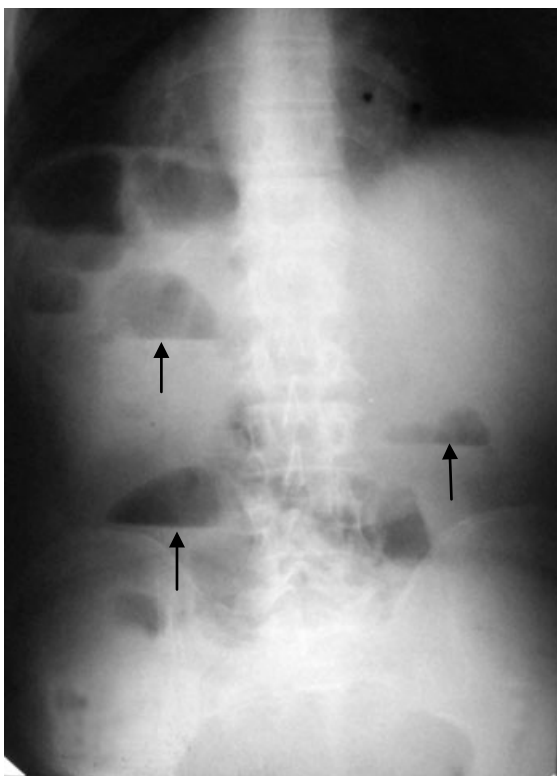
Abdominal plain film. Air-fluid levels in patients with small bowel obstruction. Note the dilatation of the air-filled loops
